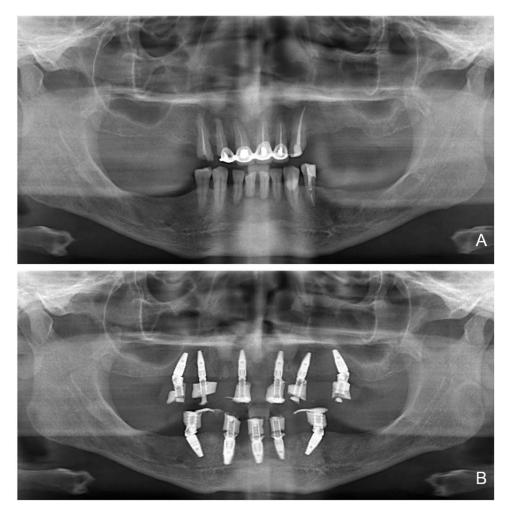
Radiographs. (A) Pre-operative panoramic radiograph. (B) Post-operative panoramic radiograph.
